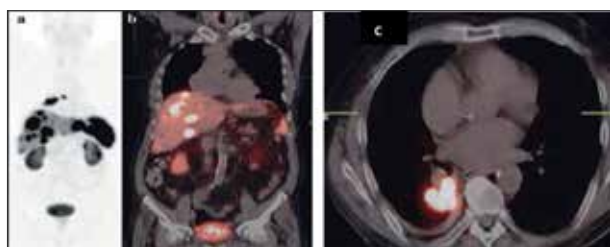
Magnetic resonance image of the abdomen: metastatic liver lesions, confirmed by positron emission tomography scan, which showed accumulation of radioactive fluorodeoxyglucose in the liver, as well as in the right lung
